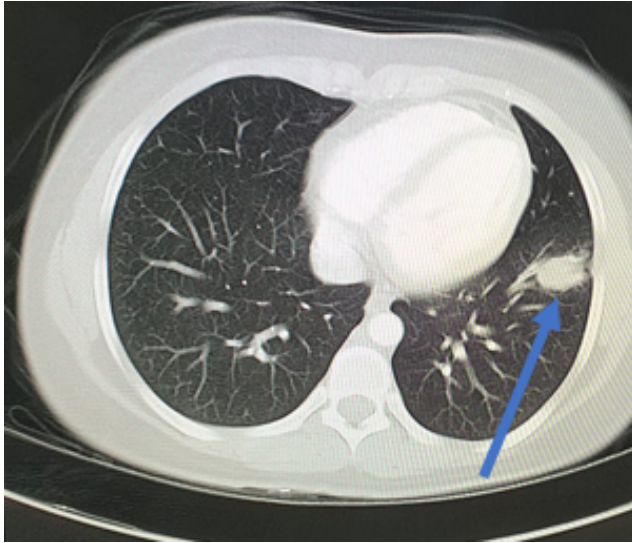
CT image showing solitary nodule in left lung
